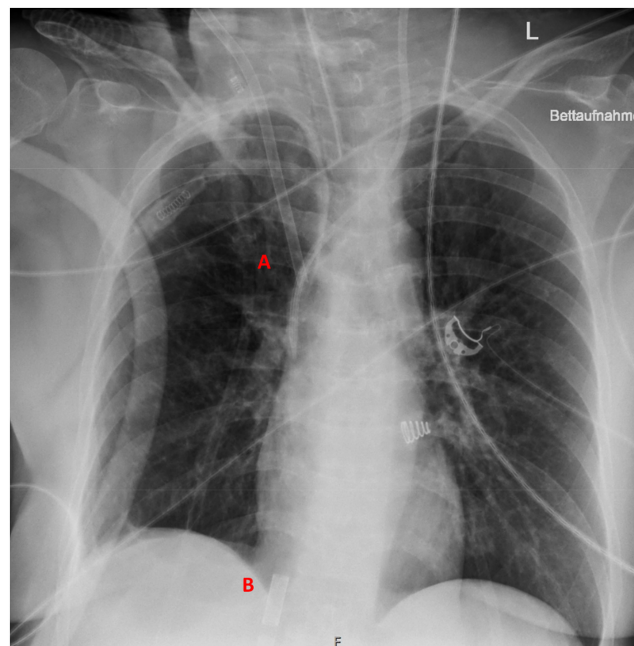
Chest X-ray on admission showing pulmonary hyperinflation without ARDS-typical infiltrations. (A) Jugular ECMO cannula, (B) femoral ECMO cannula.
